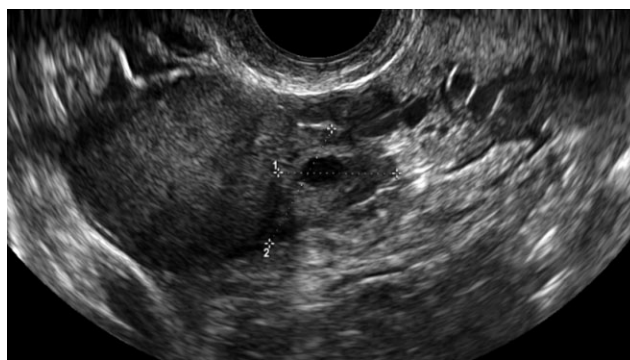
Gray-scale ultrasound image of ovarian metastasis from lung adenocarcinoma, showing a solid tumor with lobulated margins adjacent to normal ovarian parenchyma, the latter marked by calipers.
